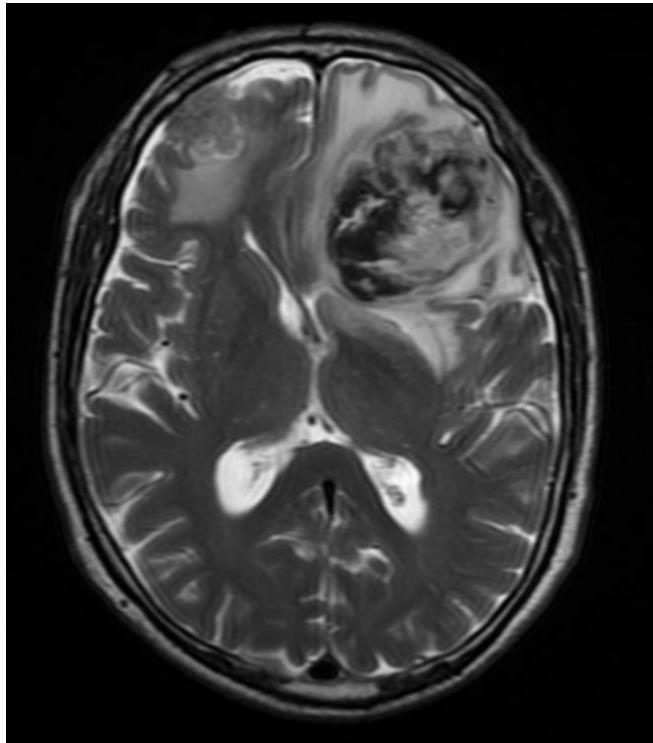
Axial contrast enhanced T2 brain MRI.
